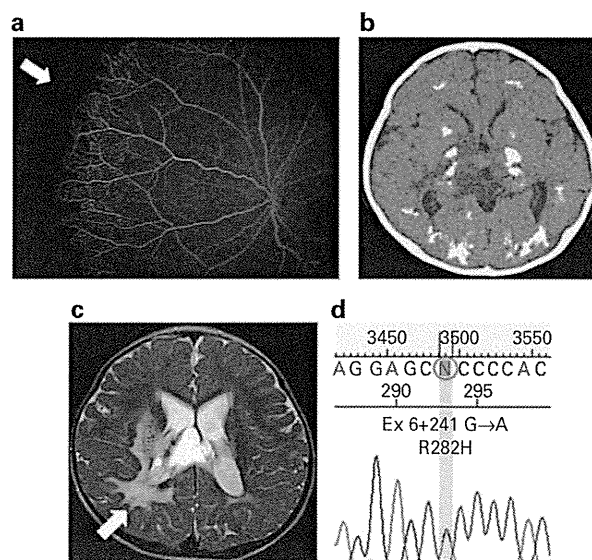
(a) Fluorescein angiogram. The arrow indicates an avascular peripheral zone in the left eye, which suggests retinal detachment. (b) CT of the brain. CT of the brain revealed extensive intracranial calcification, which is characteristic to CRMCC. (c) T2-weighted magnetic resonance imaging of the brain. The arrow indicates high signals within the white matter of the right parietal lobe, suggesting the presence of leukoencephalopathy. (d) Sequence tracing showing a *TINF2* mutation in PBLs of the patient. Sequence tracing showing a heterozygous G to A mutation (Ex 6 + 241 G→A, R282H) in *TINF2*.
